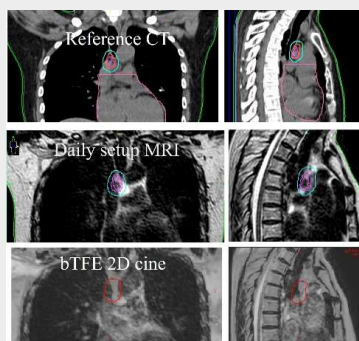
Patient planning CT, daily MRI using T2 TSE 3D sequence, and bTfE 2D cine image for motion monitoring.
